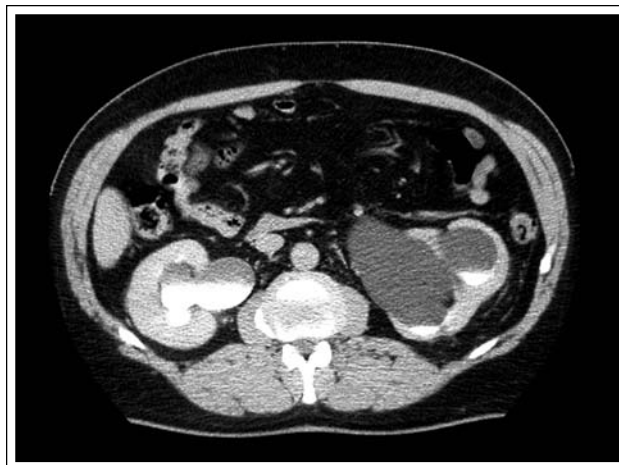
Massive left hydronephrosis demonstrated on the abdominal CT Scan with poorly functioning left kidney. There is mild to moderate hydronephrosis on the right side as well, with good kidney function though.
